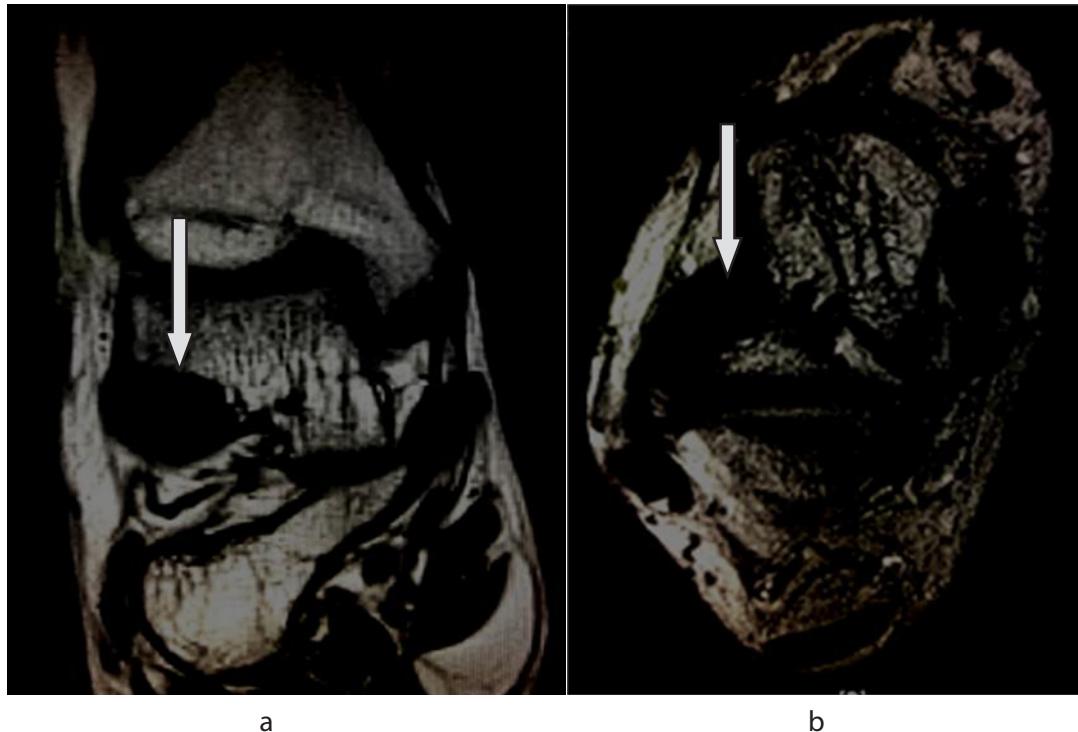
T1 weighted MRI showing coronal view (a) and axial view (b) of right ankle with hypointense lesion at the lateral process of talus (white arrow)
